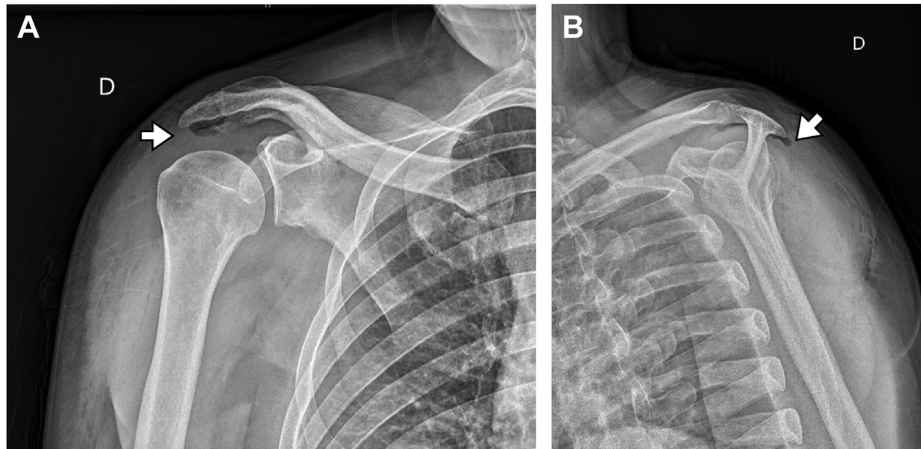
(A and B) Radiographs show air lucencies bubbles on subacromial space and within the soft tissues.
